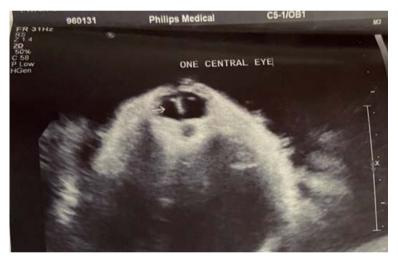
Ultrasound picture showing a single central eye with two pupils.
